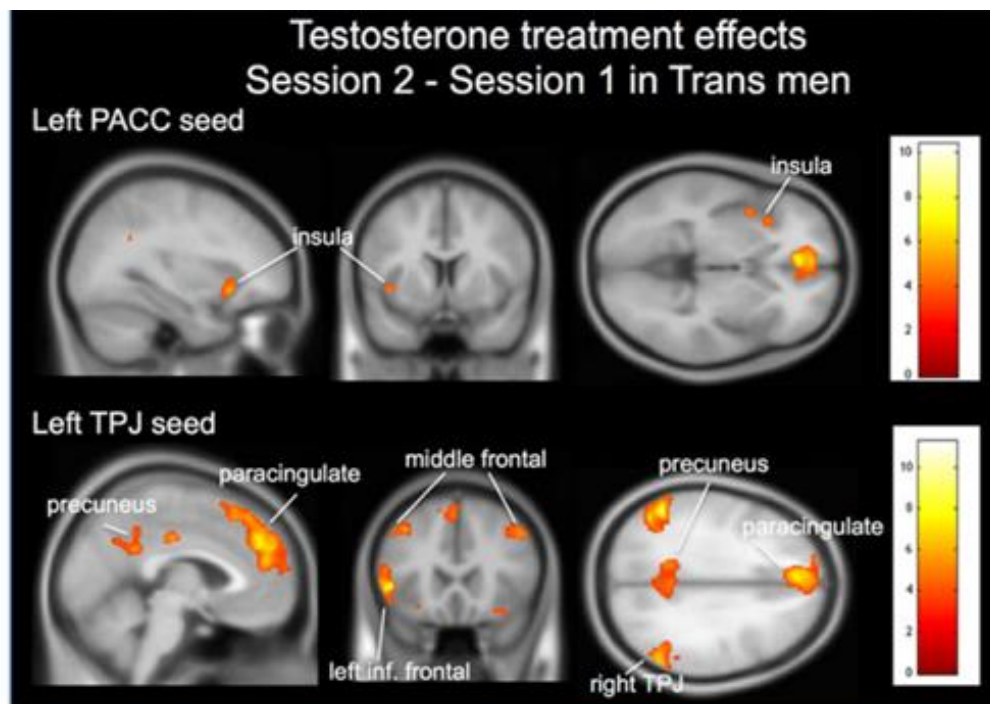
Testosterone treatment effects on functional connectivity between session 1 and 2 in trans men as depicted via MRI scan. Paired t-test results show increases in functional connectivity with treatment for the left pACC and TPJ. These areas linked to networks processing own body perception in the context of self, which displayed initially weaker functional connections, show significantly increased connectivity with testosterone treatment. Color bars indicate t-statistic. Modified based on (Burke et al., 2018).
